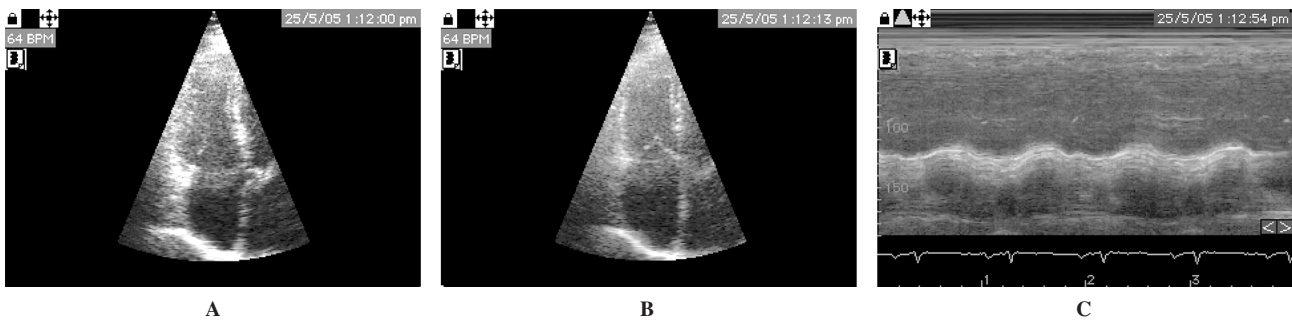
Echocardiographic images obtained in a patient with primary dilated cardiomyopathy and reduced right ventricular function (confirmed by a reduced right ventricular ejection fraction at rapid response thermodilution). Right ventricular end-diastolic (A) and end-systolic (B) areas: the calculated area shrinkage is around 20%. The tricuspid annular plane systolic excursion (C) is 9 mm.
